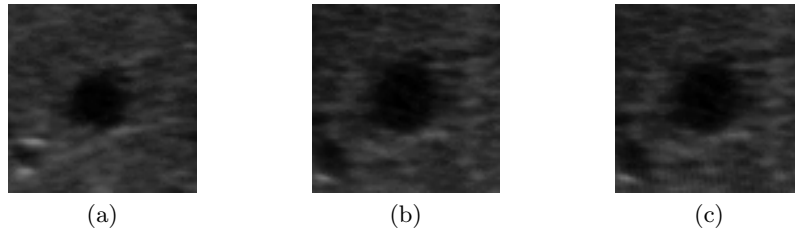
Examples of ultrasound images in a sequence. These images show the target vessel in different frames. (a) 1st frame. (b) 37th frame. (c) 38th frame.
